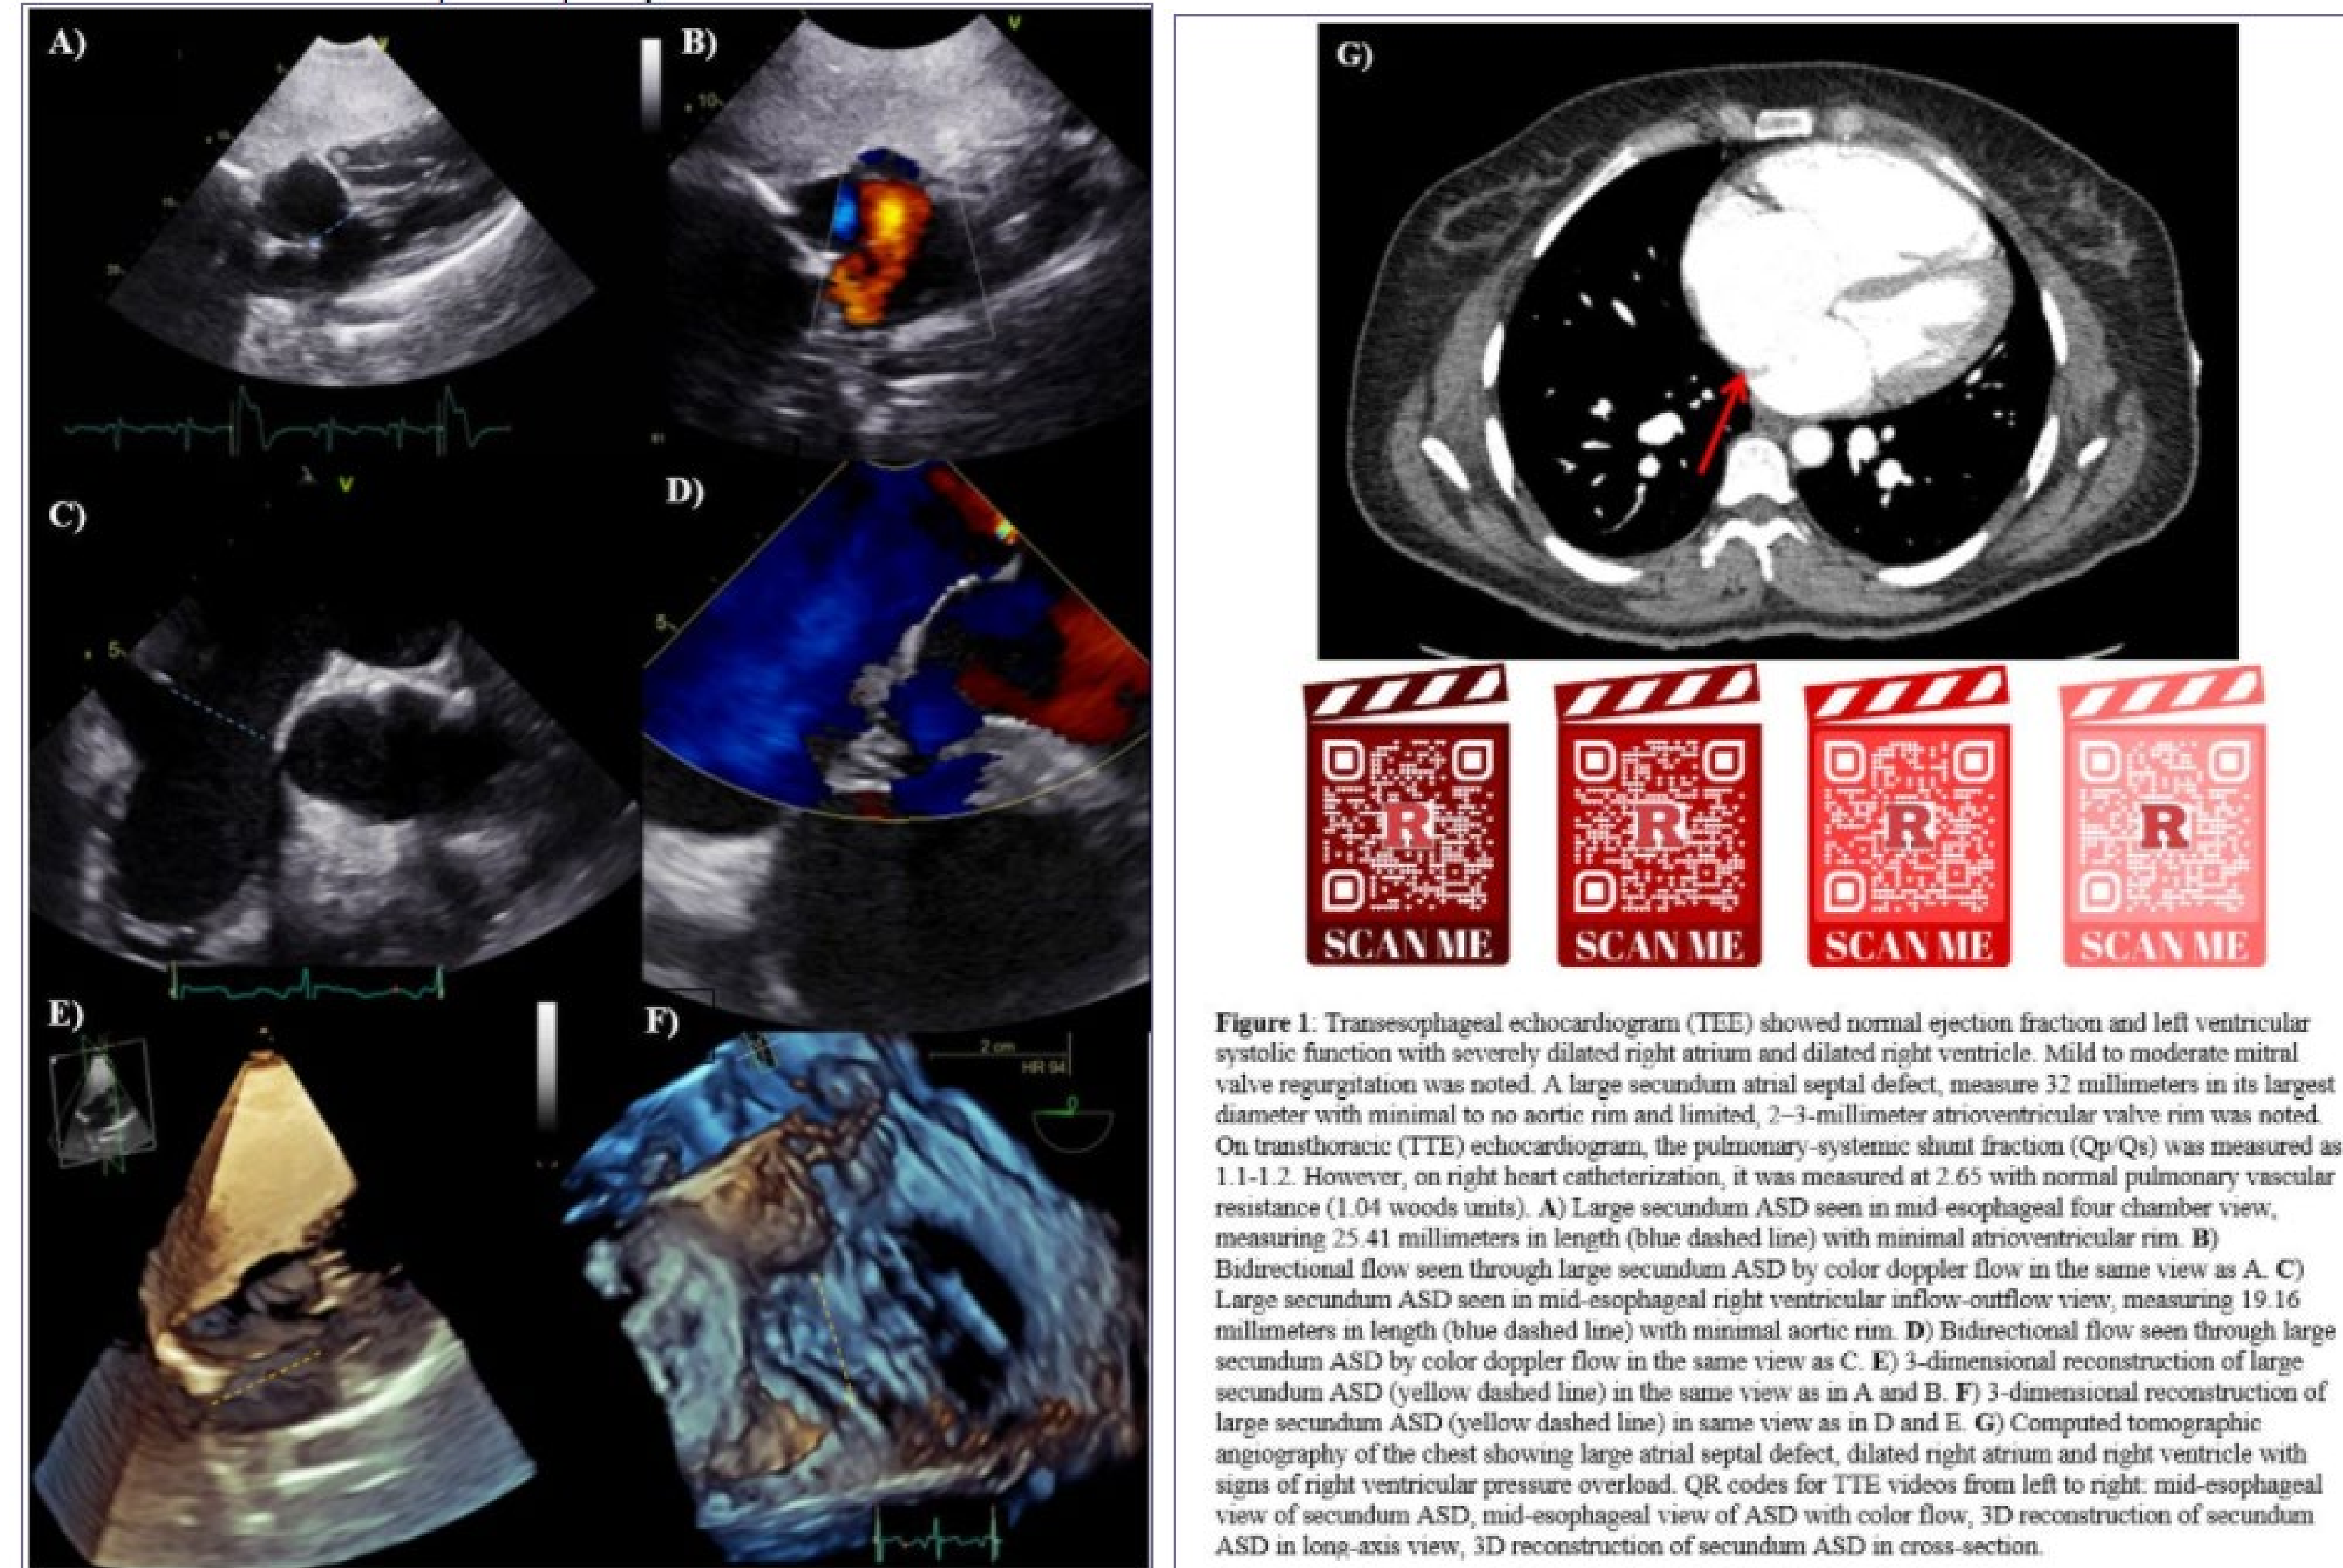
Transesophageal echocardiogram (TEE) showed normal ejection fraction and left ventricular systolic function with severely dilated right atrium and dilated right ventricle. Mild to moderate mitral valve regurgitation was noted. A large secundum atrial septal defect, measure 32 millimeters in its largest diameter with minimal to no aortic rim and limited, 2–3-millimeter atrioventricular valve rim was noted. On transthoracic (TTE) echocardiogram, the pulmonary-systemic shunt fraction (Qp/Qs) was measured as 1.1-1.2. However, on right heart catheterization, it was measured at 2.65 with normal pulmonary vascular resistance (1.04 woods units). A) Large secundum ASD seen in mid-esophageal four chamber view, measuring 25.41 millimeters in length (blue dashed line) with minimal atrioventricular rim. B) Bidirectional flow seen through large secundum ASD by color doppler flow in the same view as A. C) Large secundum ASD seen in mid-esophageal right ventricular inflow-outflow view, measuring 19.16 millimeters in length (blue dashed line) with minimal aortic rim. D) Bidirectional flow seen through large secundum ASD by color doppler flow in the same view as C. E) 3-dimensional reconstruction of large secundum ASD (yellow dashed line) in the same view as in A and B. F) 3-dimensional reconstruction of large secundum ASD (yellow dashed line) in same view as in D and E. G) Computed tomographic angiography of the chest showing large atrial septal defect, dilated right atrium and right ventricle with signs of right ventricular pressure overload. QR codes for TTE videos from left to right: mid-esophageal view of secundum ASD, mid-esophageal view of ASD with color flow, 3D reconstruction of secundum ASD in long-axis view, 3D reconstruction of secundum ASD in cross-section.
